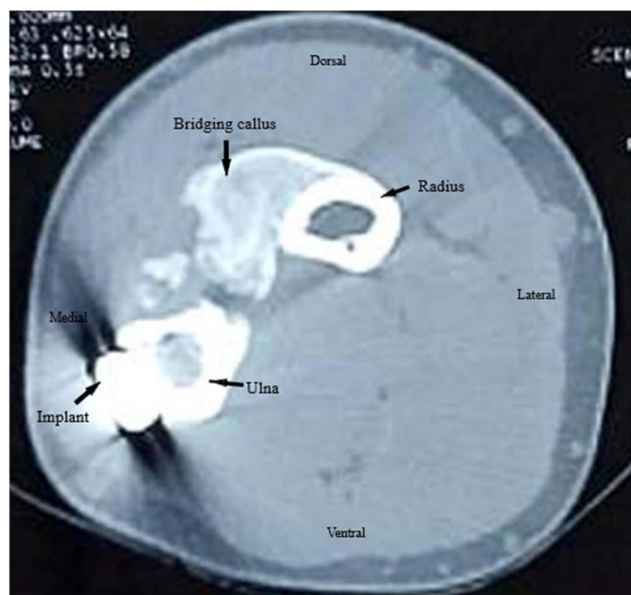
Axial computed tomography view of the right forearm showing implant in-situ and synostosis formation between the radius (posteromedial) and the ulna.
